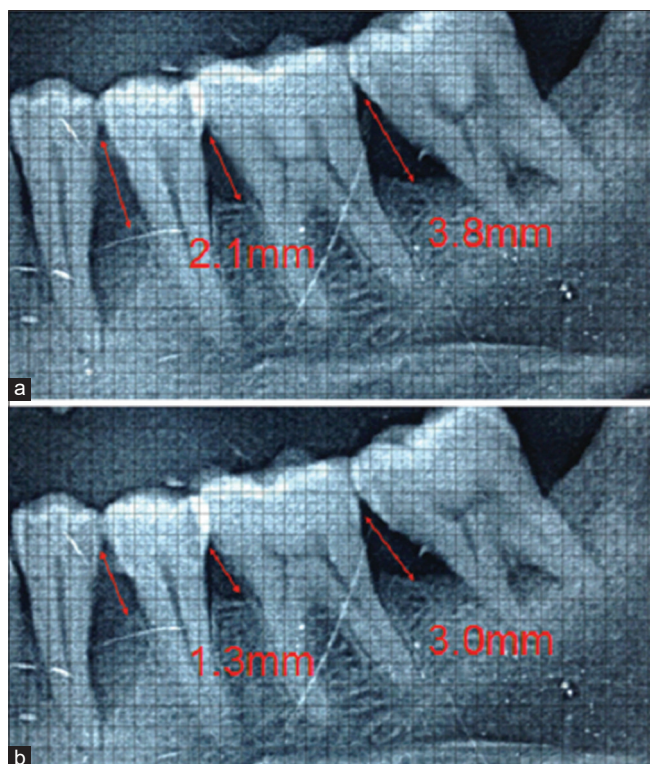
(a) Radiographic bone level at baseline. (b) Radiographic bone level after 6 months
